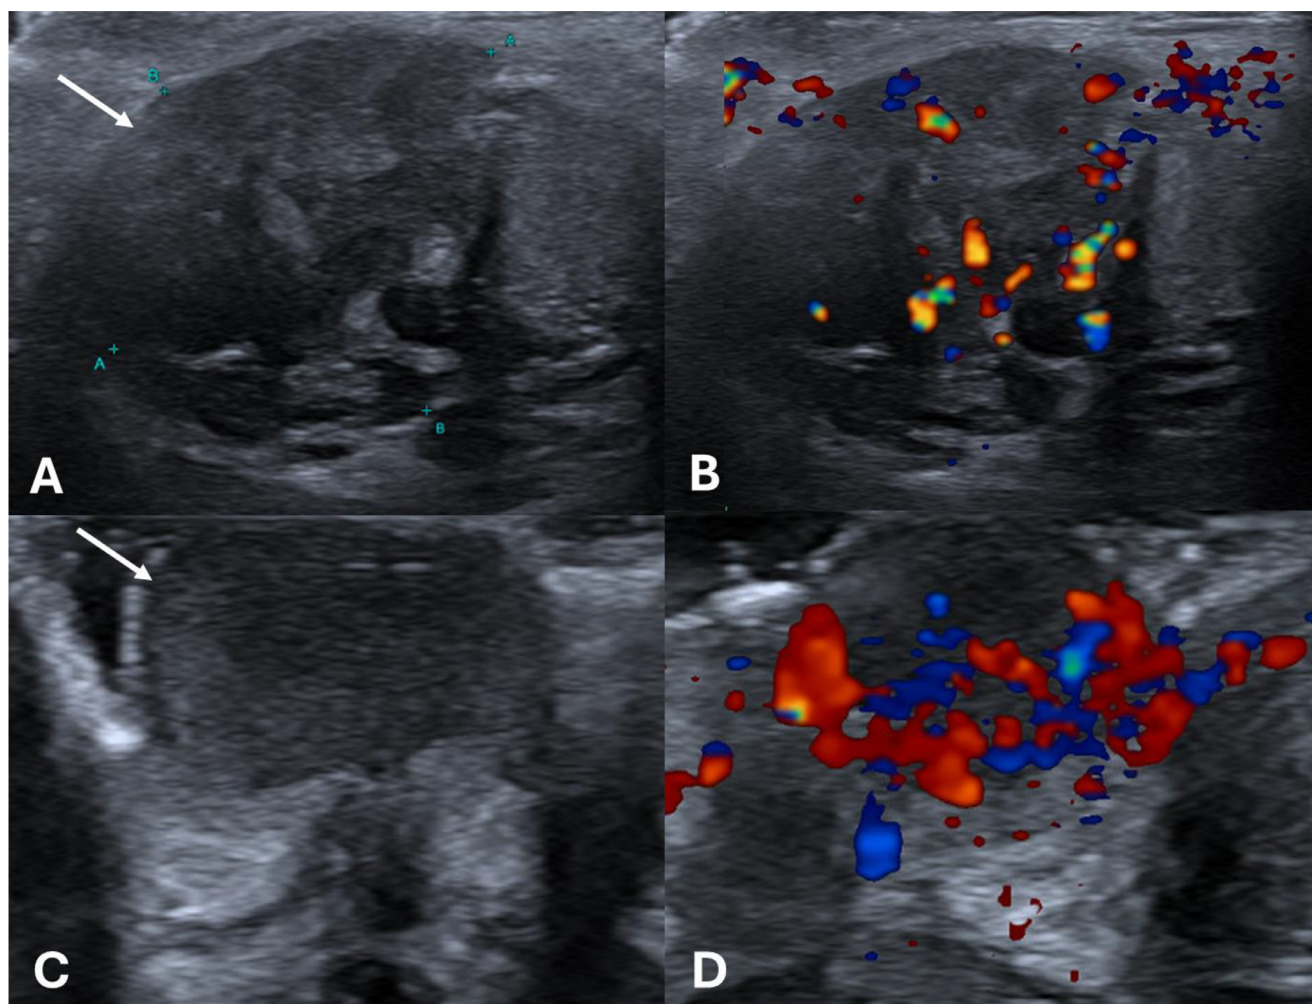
Ultrasound of the testes and inguinal region. (A) Hypoechoic solid right paratesticular lesion (white arrow). (B) This demonstrated marked internal vascularity on color doppler imaging. (C) About 12 mm superficial hypoechoic nodule within the umbilicus (white arrow). (D) Significant internal and peripheral vascularity on color doppler.
